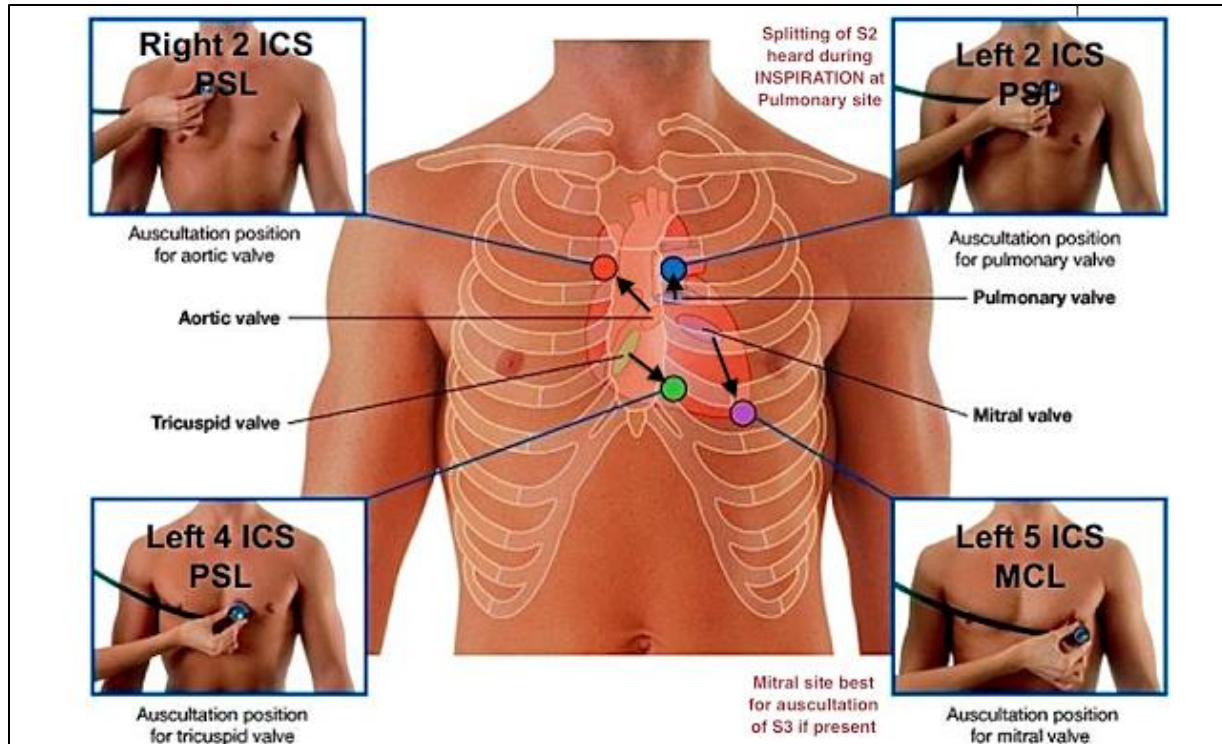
Heart sound auscultation areas. The picture shows the four major precordial auscultation areas, namely, the mitral area (left 5th ICS MCL), the tricuspid area (left sternal border), the aortic area (right 2nd ICS, parasternal line (PSL)) and the pulmonary area (left 2nd ICS PSL).
